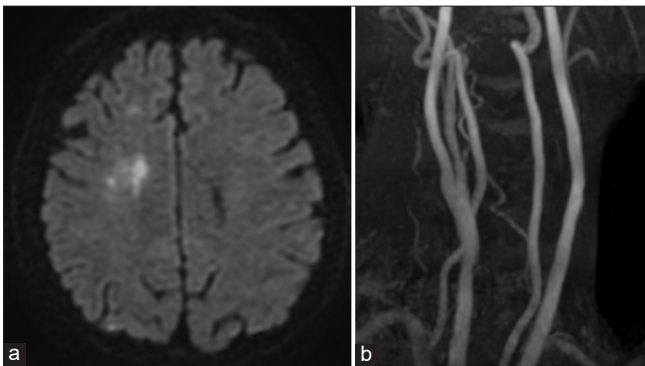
(a) Postoperative MR imaging revealed no new cerebral infarction. (b) Preoperative MR angiography of the neck showed the patency of the right internal carotid artery (ICA) and external carotid artery (ECA).
